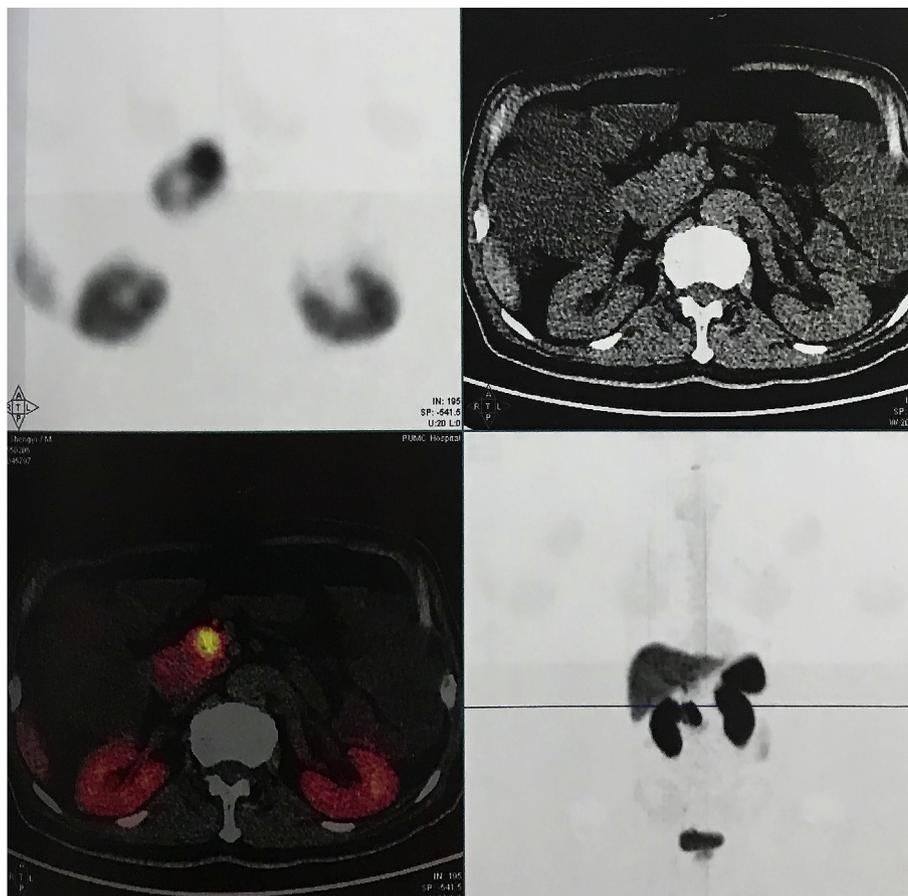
$^{68}\text{Ga}$ -DOTATATE PET-CT showing high expression of somatostatin receptor at the pancreatic mass.
